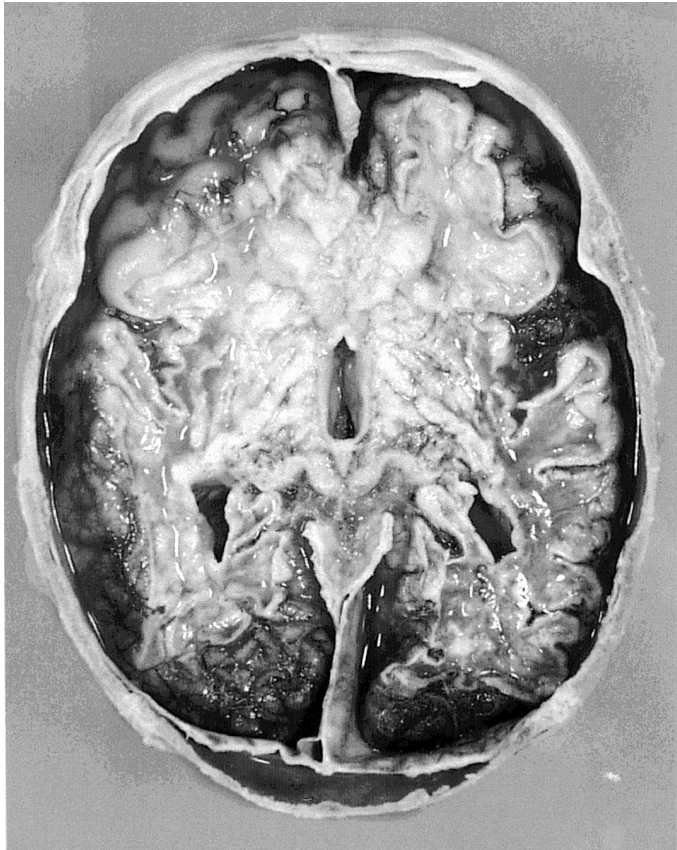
View at the horizontal plane of the upper half of the brain which has been cut together with the calvarium from the base; Case 2. The X-ray examinations shown in Figs. 1–3 were made in this stage of autopsy. There is a massive general destruction of the white matter and shrinking and general softening of the brain. Despite this condition, the X-ray method gave a good result (Fig. 3).
